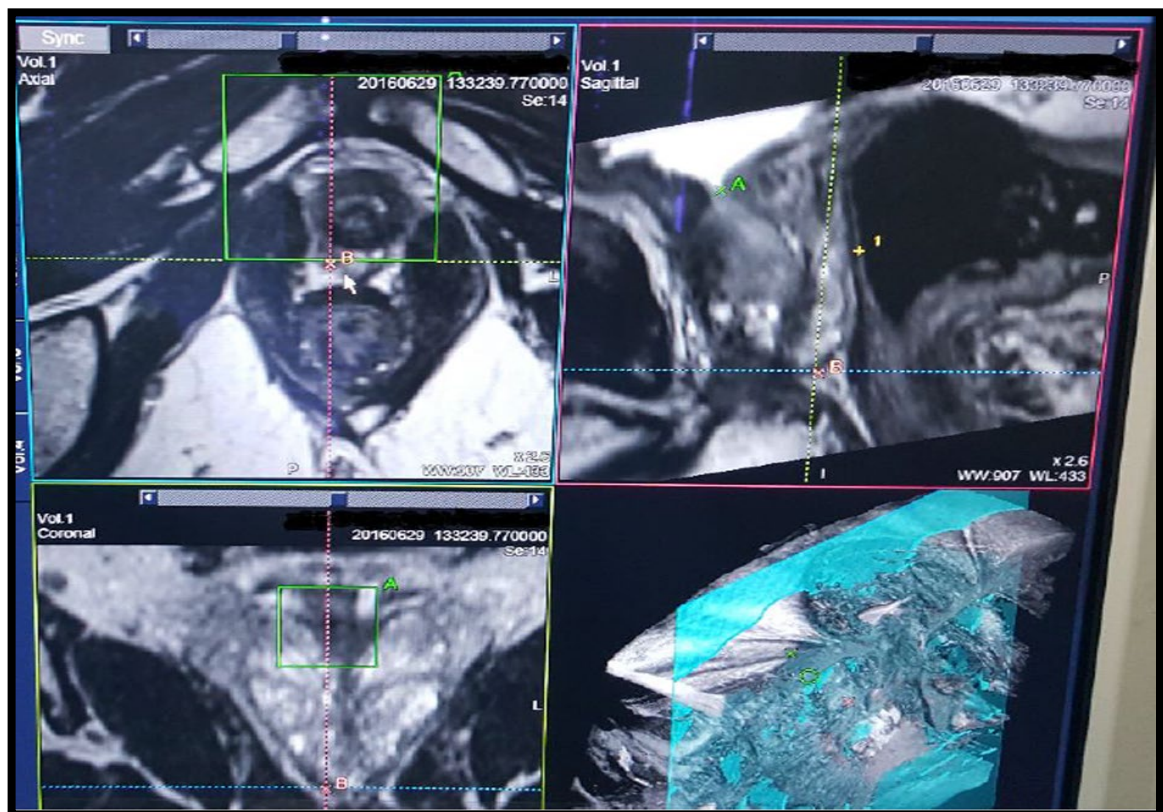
An MRI of the prostate taken before the biopsy is used as a map.
